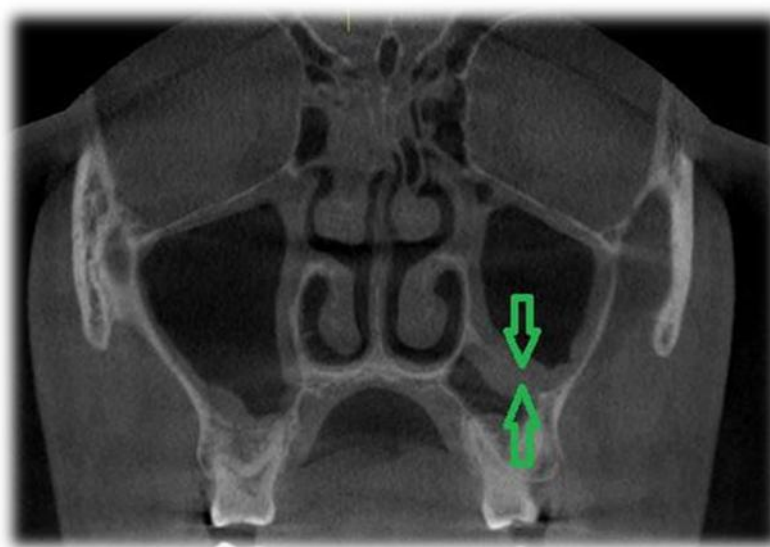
CT scan of chronic hyperplastic sinusitis [23].
